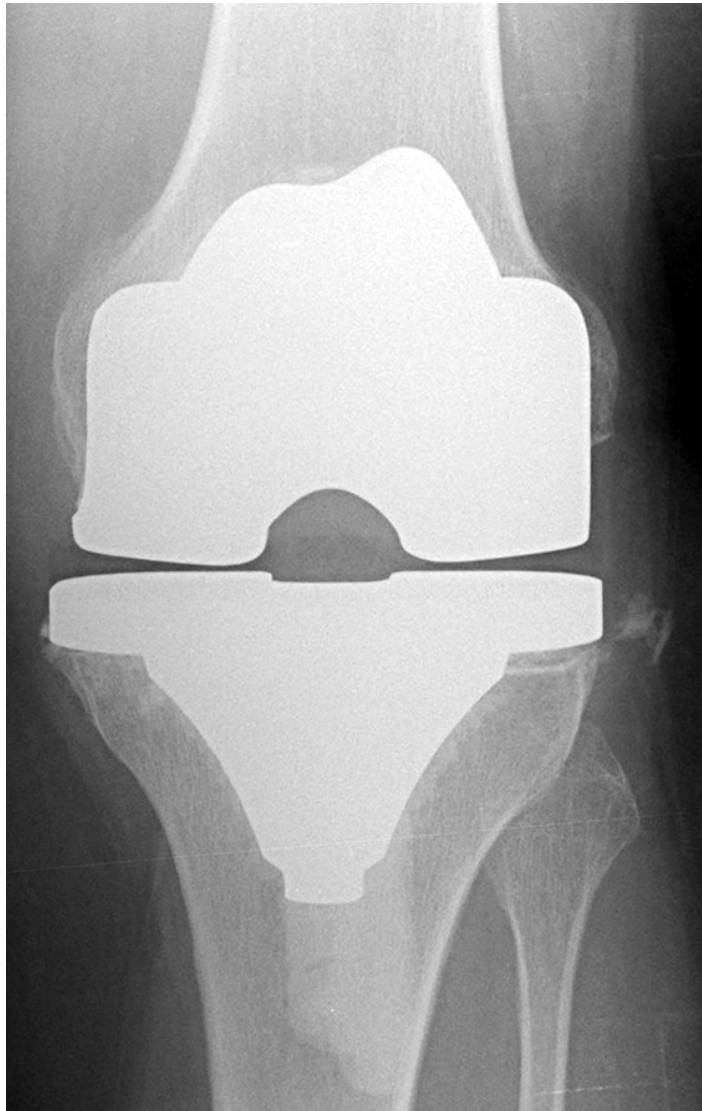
Scanned life size image of AP radiograph of a successfully implanted size 7 Scorpio CR TKR with 0 degree tibial slope using the known dimensions of the tibial tray insert and femoral component (^{130;131})
